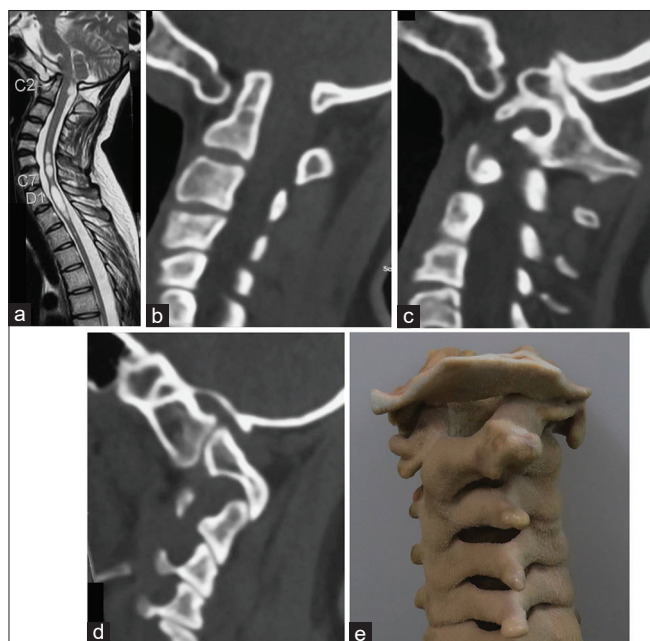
Preoperative images. (a) T2-weighted magnetic resonance imaging showing basilar invagination. Chiari formation and syringomyelia can be observed. (b) Computed tomography scan showing basilar invagination. Assimilation of the atlas can be seen. (c) Computed tomography scan with the cut passing through the left C1-2 articulation. The vertebral artery foramen is high riding. The facet of C1 is markedly anterior and rostrally located, making direct exposure for screw implantation difficult. (d) Computed tomography scan with the cut passing through the right facet articular surface. The articular surfaces of the facets of atlas and axis are positioned vertically. (e) Three-dimensional model of the craniocervical junction shows the relationship of the lateral masses with the vertebral artery. The sizes of the pedicles can be appreciated clearly
